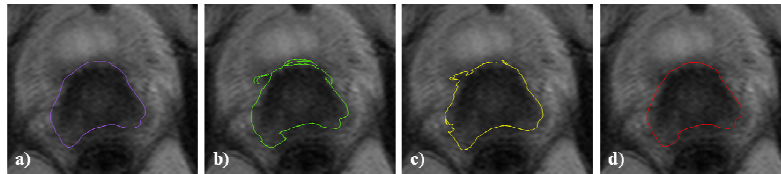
A 2D representation of the deformed contours of the prostate on the correspondent T2w-MR image. a) WSR; b) MCB; c) PWC; d) AMR.
